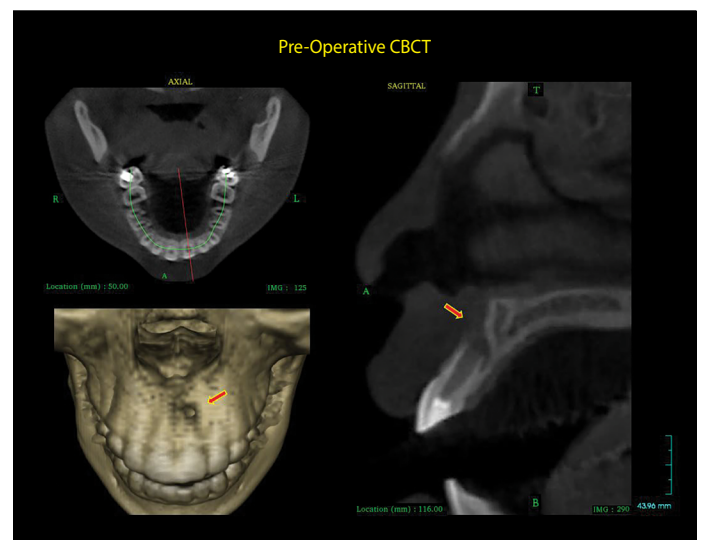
Preoperative CBCT. (a) Cross-sectional view with intersection transverse line on the midline of the left maxillary central incisor. (b) 3D reconstruction image indicates no labial cortical plate at the apical part of the root. (c) Sagittal view image reveals an open apex of the tooth and no labial cortical plate
